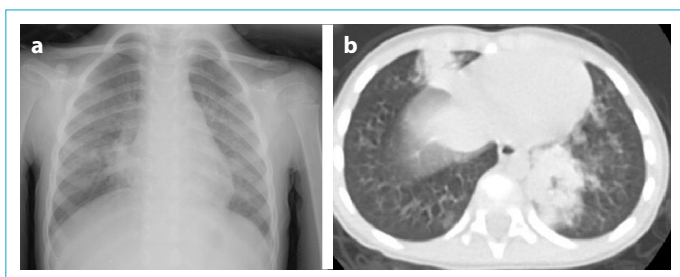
(a) 3 years old girl admitted to the emergency room with complaints fever and cough. There was a bilateral patchy consolidation areas in chest X-ray. (b) After two days from chest X-ray, there was a patchy consolidation area with air bronchograms on CT.
